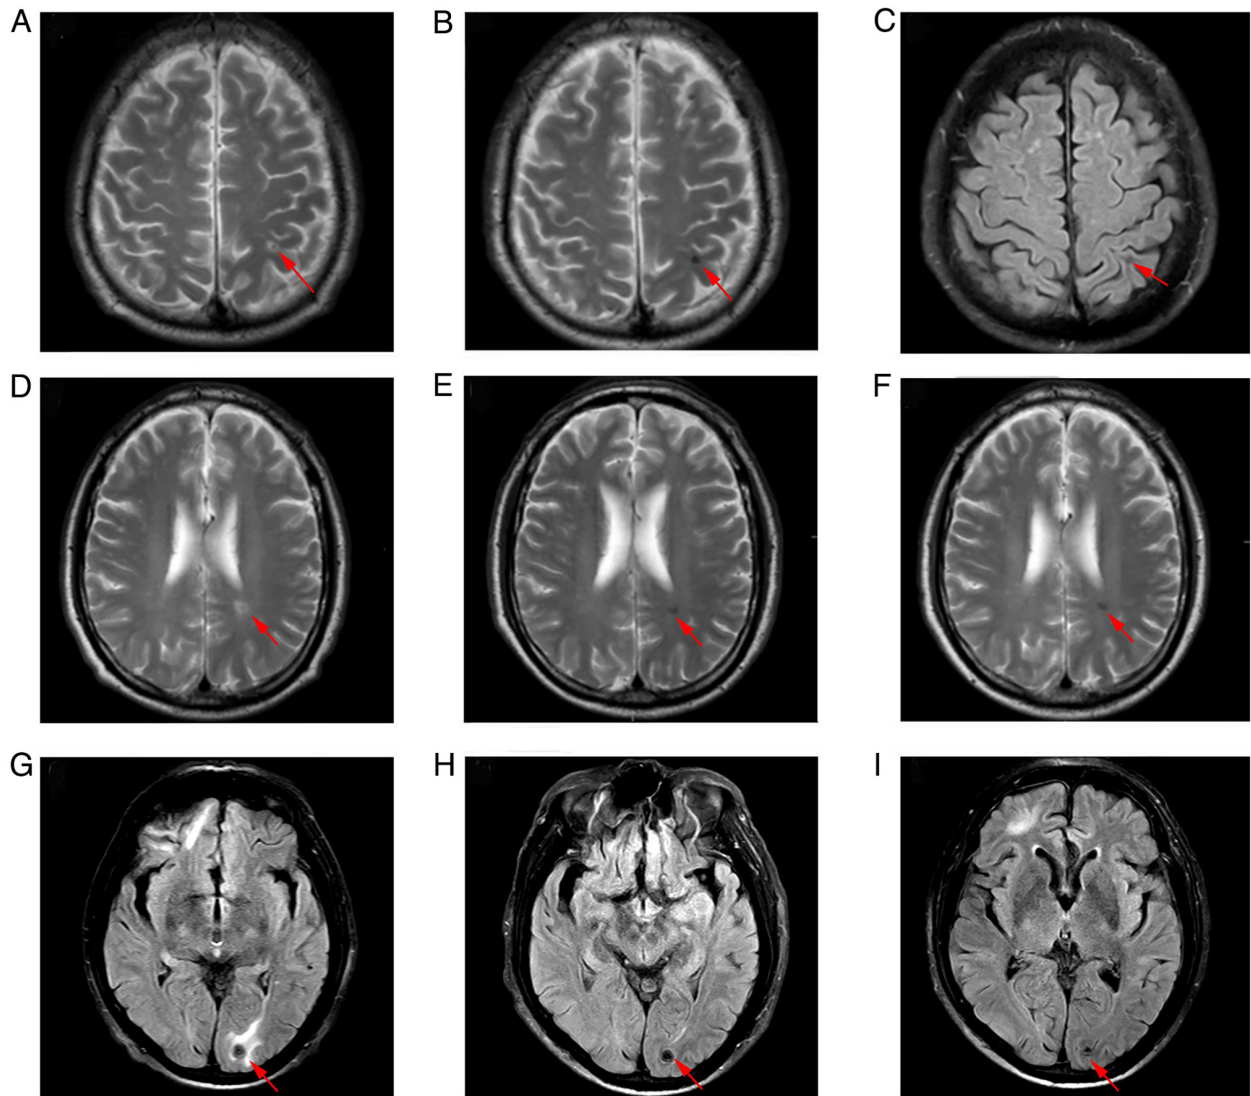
Magnetic resonance imaging of the brain. (A) The new lesions (red arrows) in the left frontal lobe, (D) left ventricle and (G) left occipital lobe after two cycles of etoposide and cisplatin chemotherapy. The lesions (red arrows) in the (B and C) left frontal lobe, (E and F) left ventricle and (H and I) left occipital lobe decreased in size after radiotherapy and four cycles of chemotherapy, and remained regressed after six cycles of chemotherapy.
